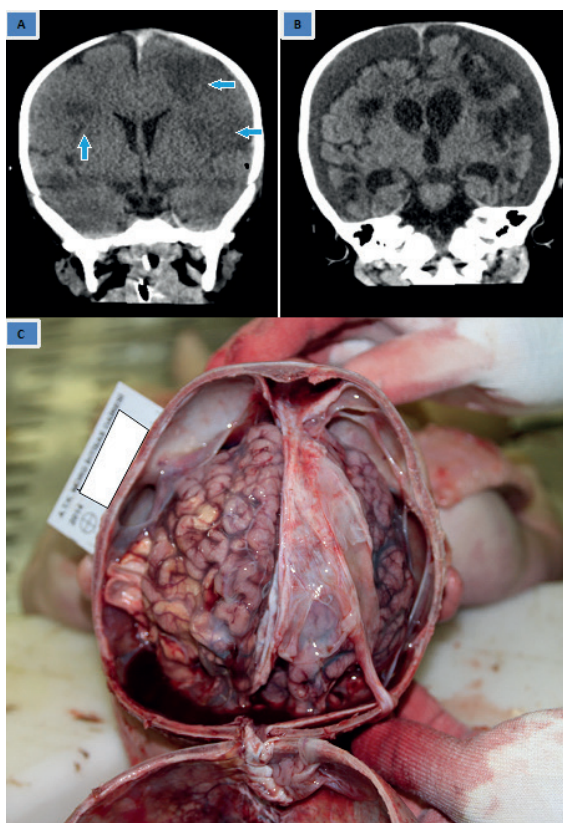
Generalized cerebral atrophy progressions due to abusive head trauma of case 1: A) a coronal non-contrast computerized tomography (CT) image, 4 days after trauma, revealed subacute hypodense lesions (arrows indicate lesions), B) a coronal non-contrast CT image, 68 days after trauma (obtained from Marmara University Hospital with permission), revealed generalized cerebral atrophy and chronic subdural effusion, C) autopsy image, 112 days after abusive head trauma (obtained from The Council of Forensic Medicine with permission) showed generalized cerebral atrophy.
